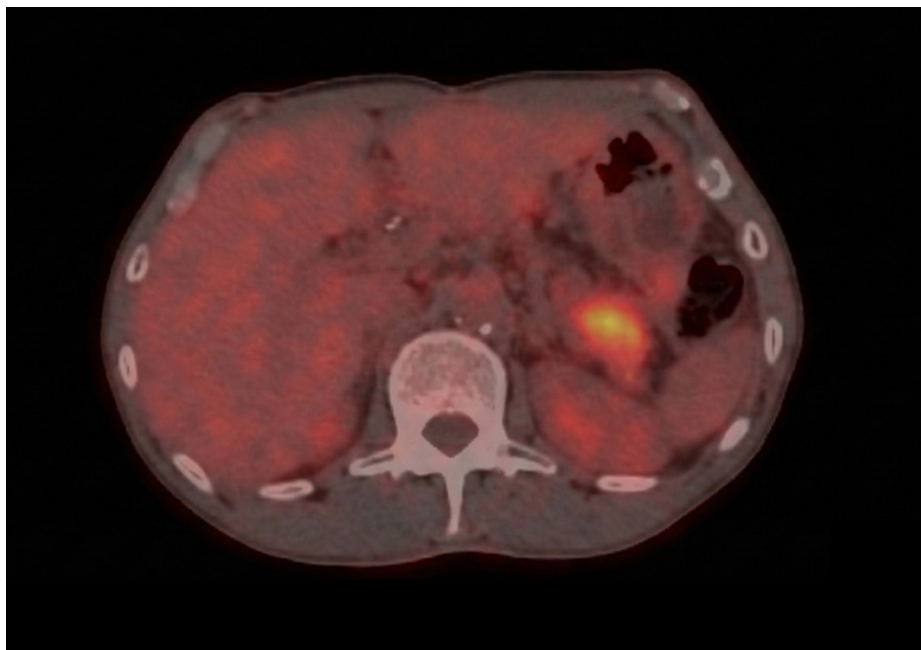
PET/CT scan showcasing the hypermetabolic lesion on the pancreatic body/tail.
